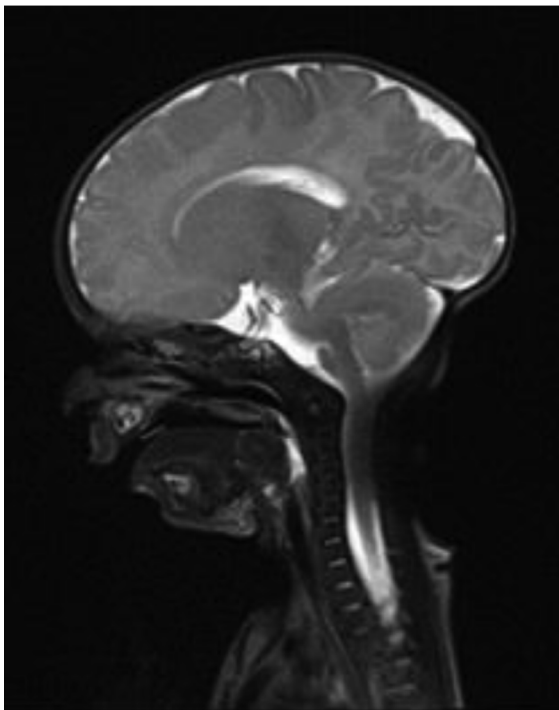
MR imagination. There is no differenet density at tongue base.
